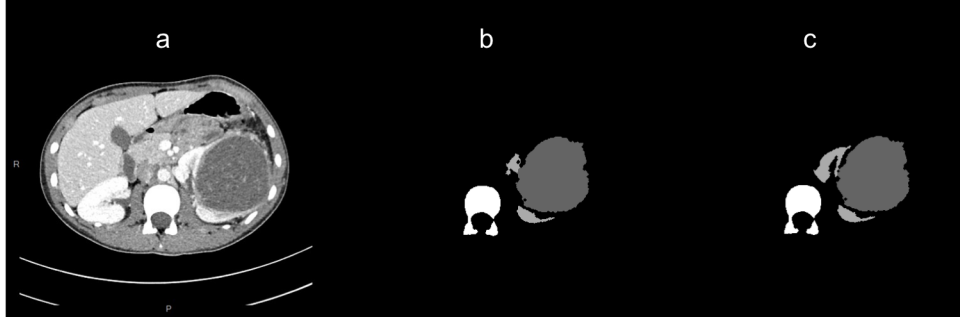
Comparison between an execution of our system with and without the adaptation phase: (a) CT-Scan, (b) segmentation without adaptation and (c) segmentation with adaptation
